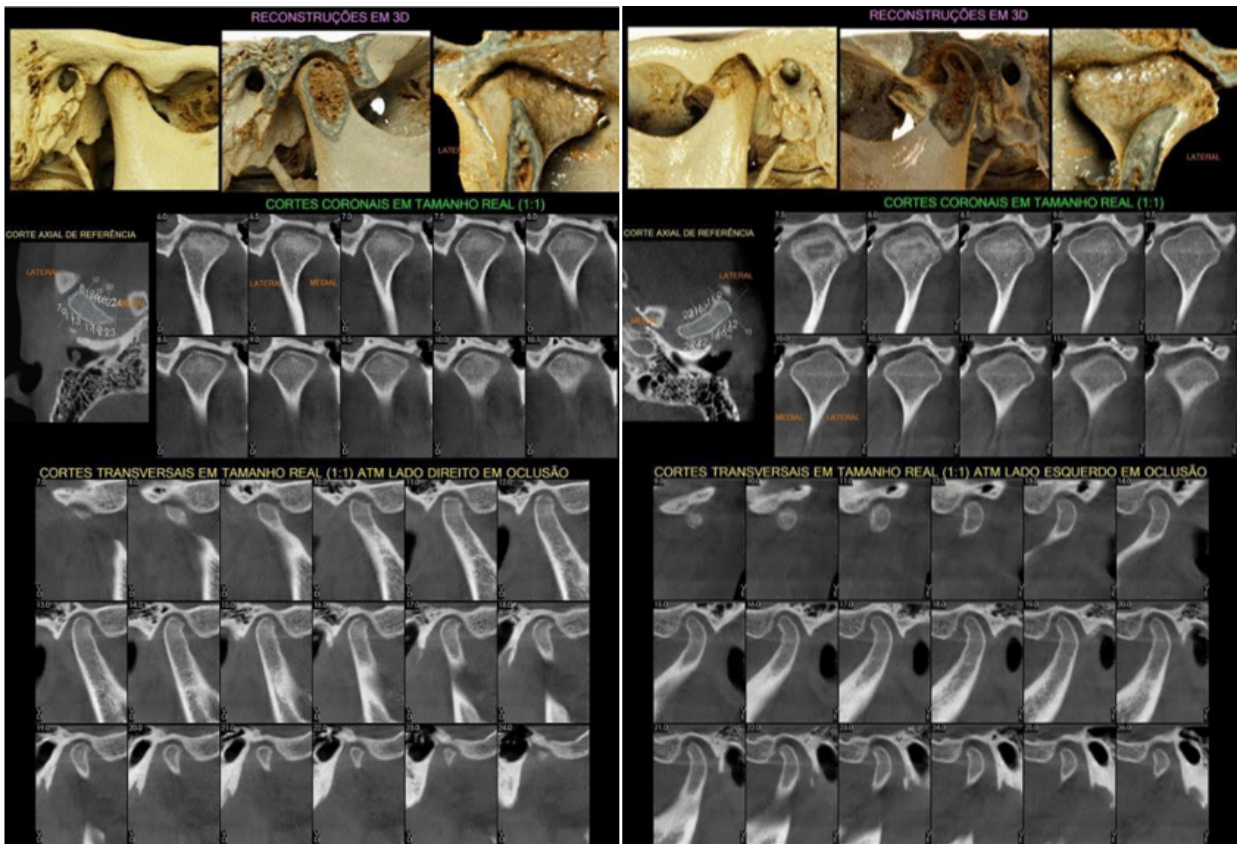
Temporomandibular joint CT.
